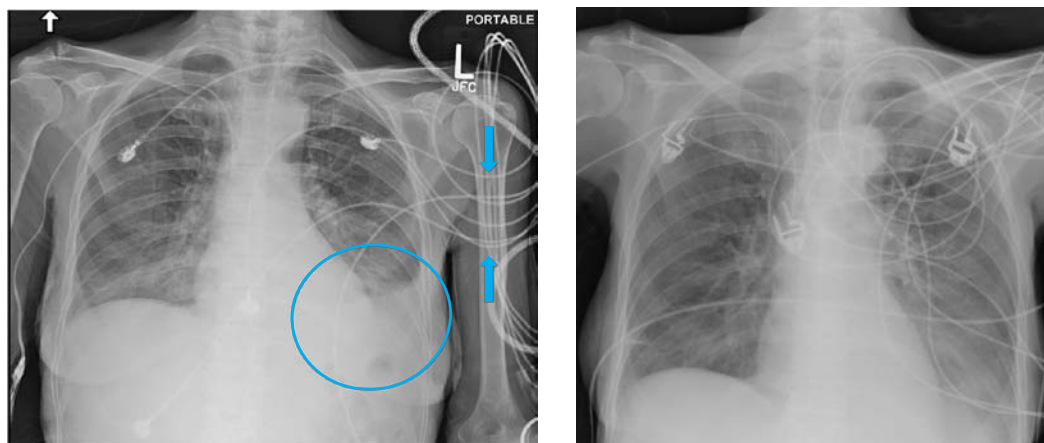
A. An upright chest radiograph demonstrating a left pleural effusion. The up arrow indicates an upright projection, but there is no rule how upright a projection has to be to include the arrow among technologists. B. More supine image that shows the effusion distributed as a hazy, ill-defined opacity over the lower left hemithorax. Without knowing the degree of angulation, comparison of pleural effusion or differentiating from a consolidation is often very difficult.
